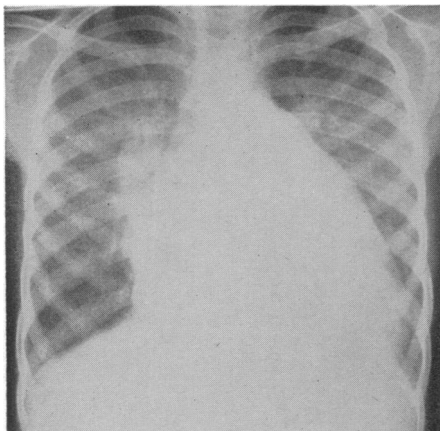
Chest radiograph of a girl aged 16 with mitral incompetence and pulmonary hypertension. The aorta is inconspicuous; main pulmonary arteries and outflow tract of right ventricle enlarged.
